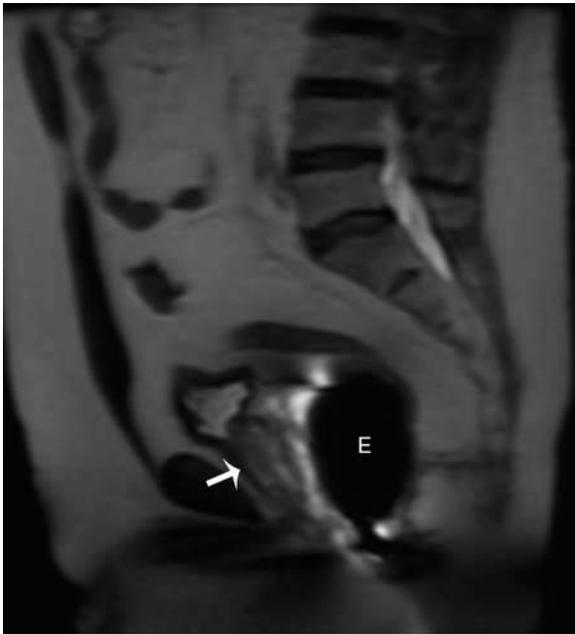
Endorectal coil placement in a 57-year-old male. Sagittal T2-weighted SSFSE image demonstrates correct placement of the endorectal coil (E) directly posterior to the prostate gland (arrow).
